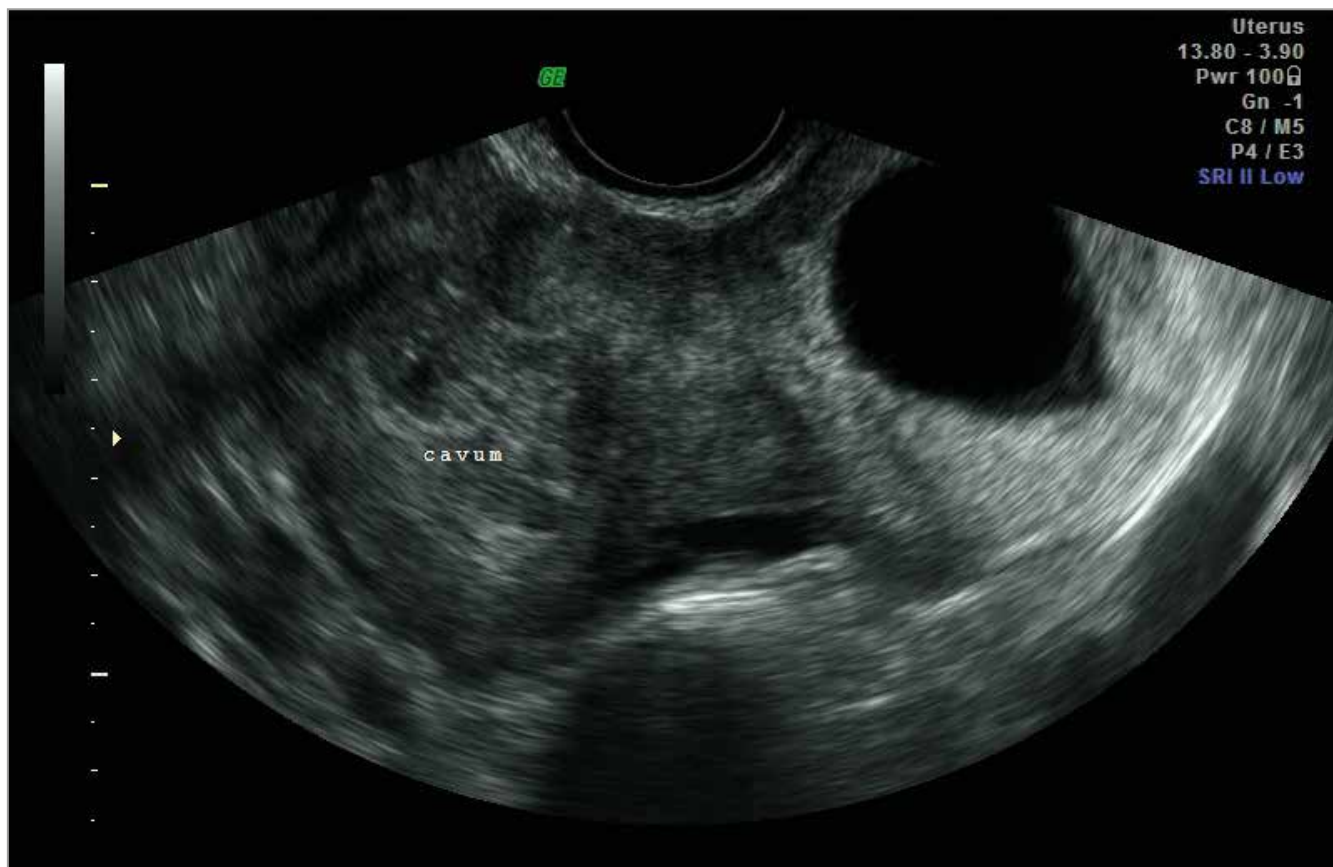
Ultrasound image of CSP on admission. Gestational sac is seen in the left isthmus of the uterus separate from the uterine cavity ("cavum").
